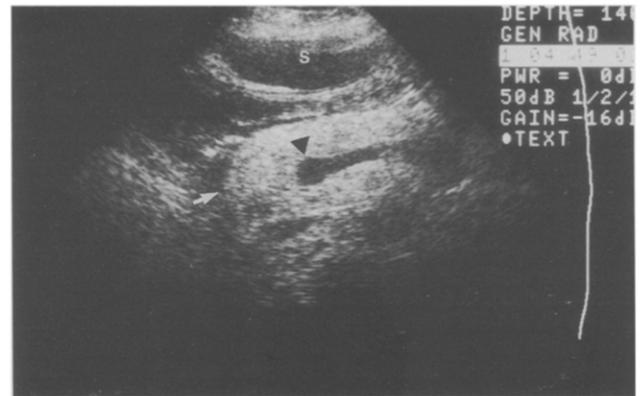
Ultrasound image (transverse plane) of the normal pancreas, following administration of simethicone-coated cellulose contrast agent. The pancreatic head (arrow) and the portal venous confluence (arrowhead) are well delineated. Note the contrast agent filled stomach (S).
